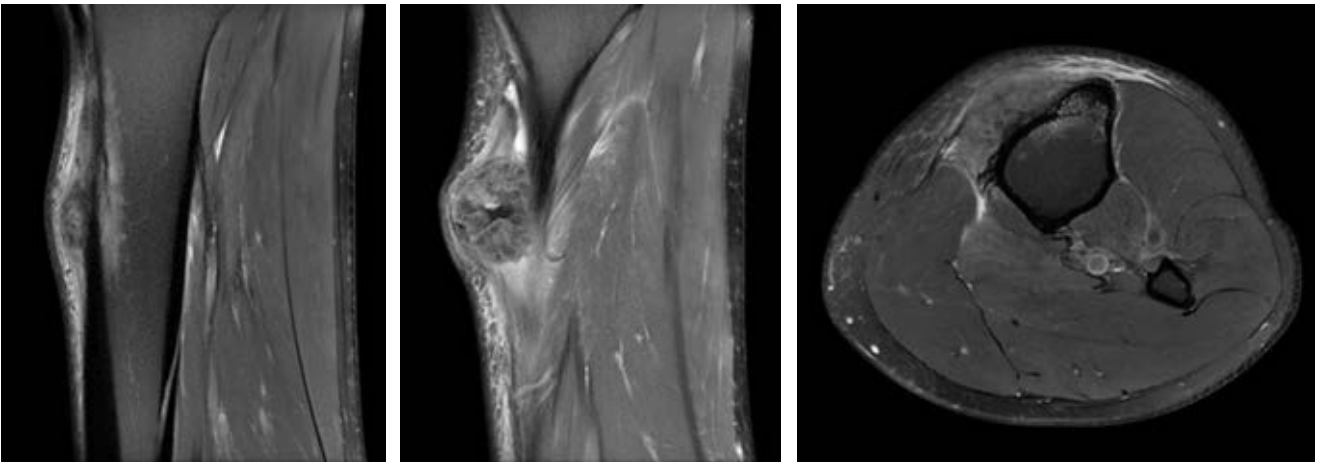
MR image of the tumor showing growth compared with previous image. Contact with the skin can be noted.
